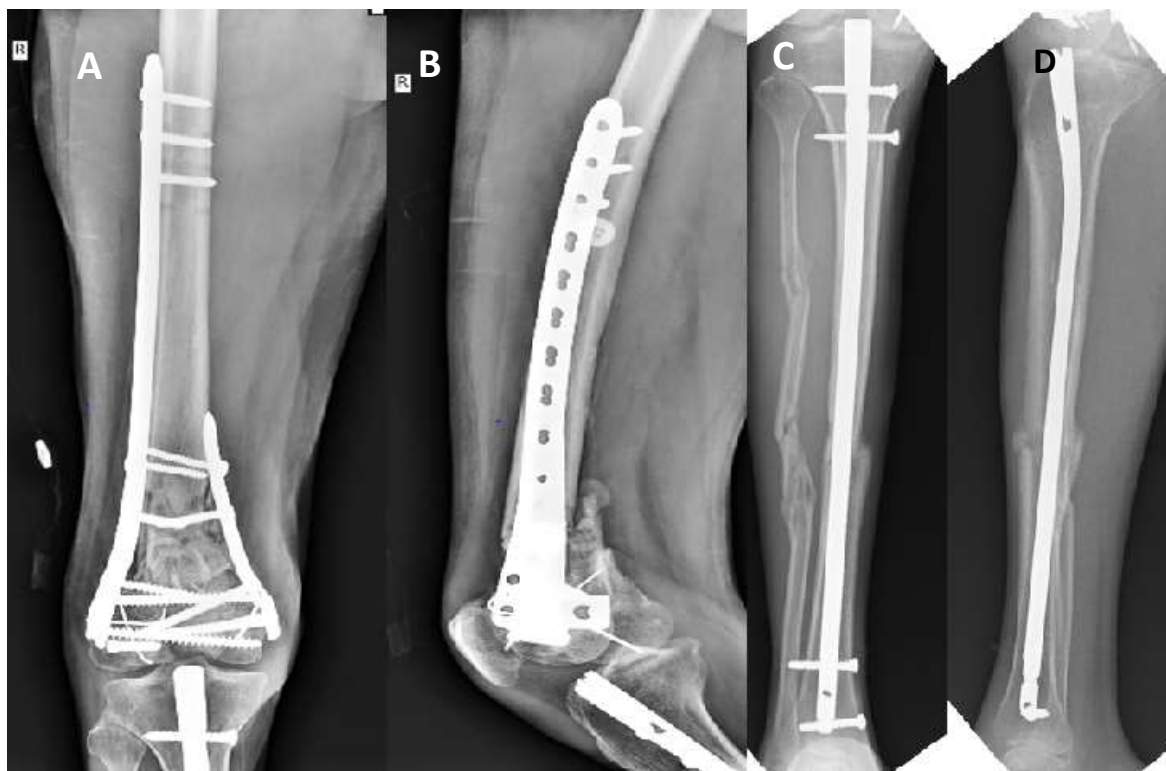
Day 2 post-operative radiographs after stage 2 surgery; A and B: Distal femur fracture revised with bi-columnar dual plating with bone grafting; C and D: Uniting fracture of mid-shaft tibia managed with intra-medullary nail and mal-uniting segmental shaft fibula fracture
